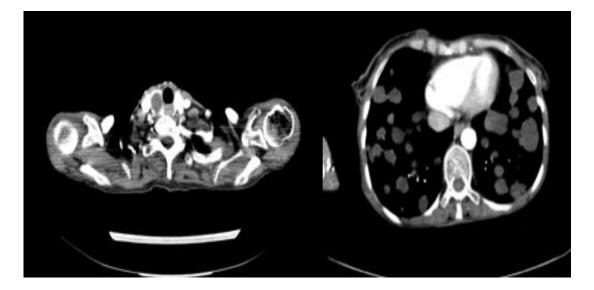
Axial view of CT scan shows cystic lesions in the right thyroid lobe and subcutaneous cysts on the right side of anterior chest wall
